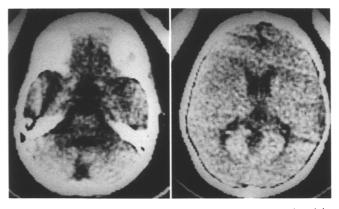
Supra- and infratentorial brain atrophy is appreciated in the late CT control (1 year after trauma) in an 8-year-old girl who had been in a traffic accident. Admission CT scan had showed diffuse brain swelling and ICP was within normal limits
